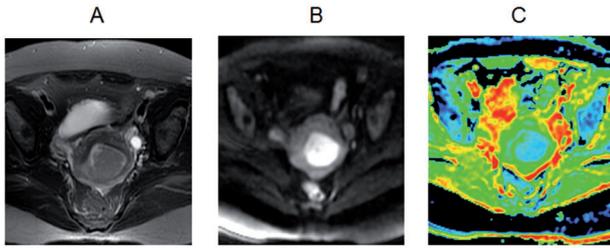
Endometrial cancer imaging. (a) T2-weighted axial image shows an ill-defined hypointense mass in the posterior myometrium. (b) Axial DWI shows marked heterogeneous hyperintense area corresponding to the tumor. (c) ADC map image shows hypointensity (restricted diffusion) compared with normal parenchyma.
